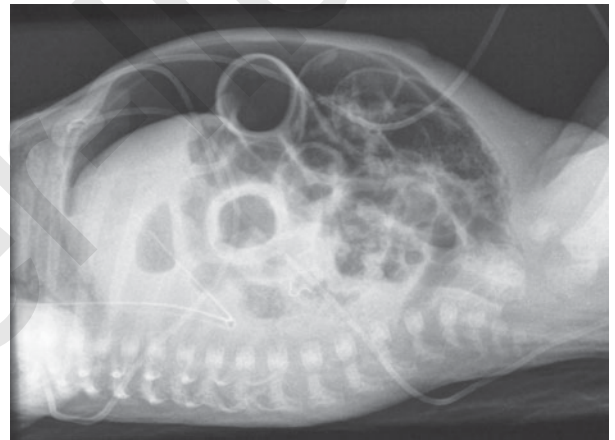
Left lateral decubitus. Decubitus x-ray in a neonate with perforated necrotizing enterocolitis. The free intraperitoneal gas rises, outlining the liver (arrowheads). Intramural gas in keeping with NEC is also demonstrated. The decubitus x-ray is also useful in the detection of air fluid levels.
